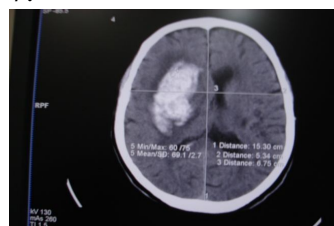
Noncontrast axial CT scan of brain of 69 years male patients showing spontaneous intracerebral haemorrhage with mass effect measured using septum pellucidum shift 14.1 mm. the GCS score of the study subject was 5.
